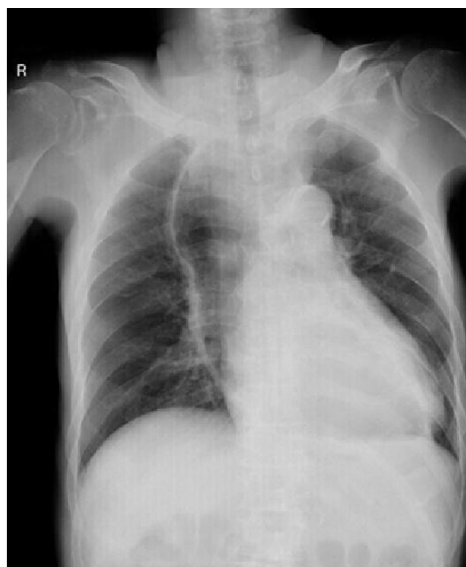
Chest radiography showing an abnormality in the mediastinum (reprinted with permission of the patient's family)
